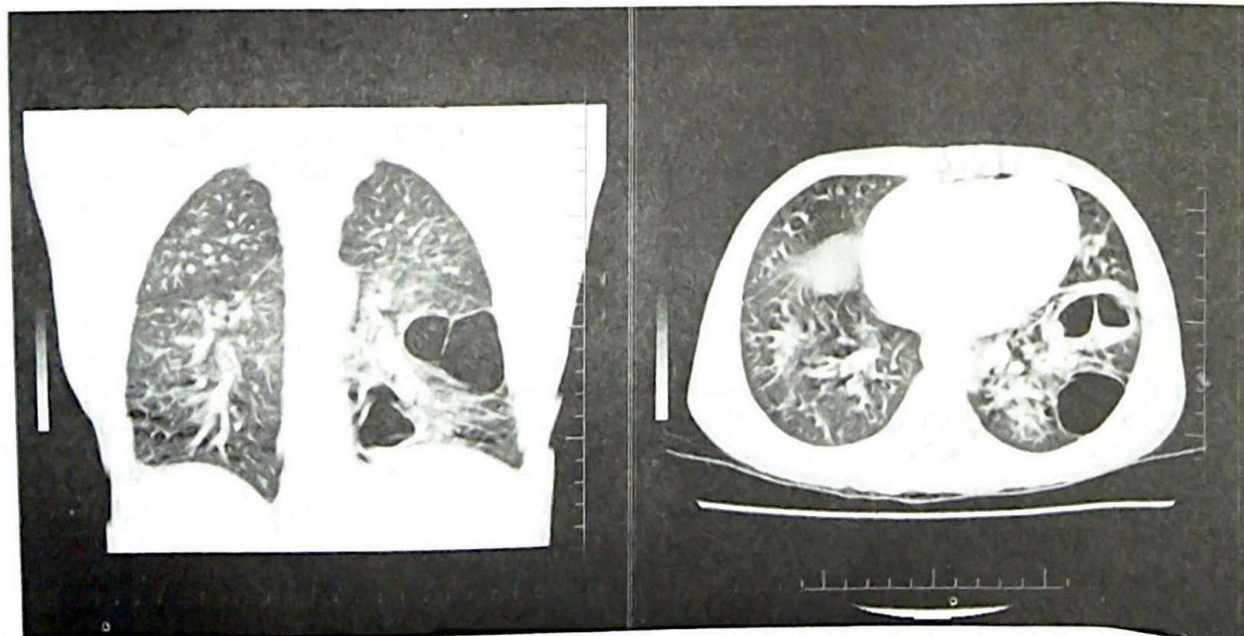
Coronal and Axial Chest CT, lung window showing multiple large thin-walled cysts in the left lower lobe, some having air-fluid levels consistent with an abscess cavity other having septations.
